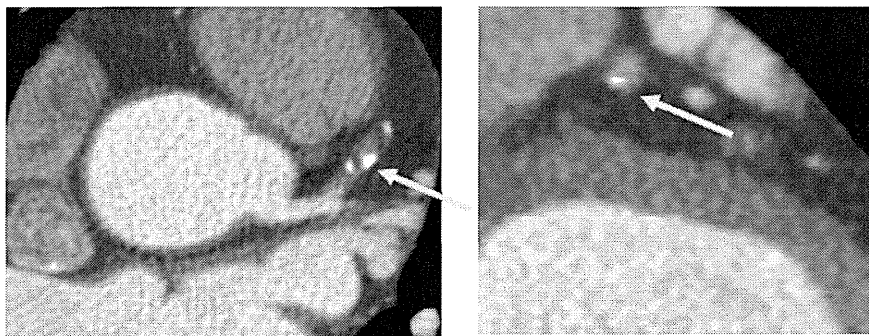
Typical images of spotty calcification in culprit coronary arteries on multislice computed tomography (CT). Left figure; axial source images of enhanced CT revealed spotty calcification (yellow arrow) in low CT area completely occluding the lumen of left anterior descending artery (LAD). Right figure; multiplanar reformation images of short axis of LAD. Spotty calcification in low CT area completely occluding the lumen of LAD can be observed.
